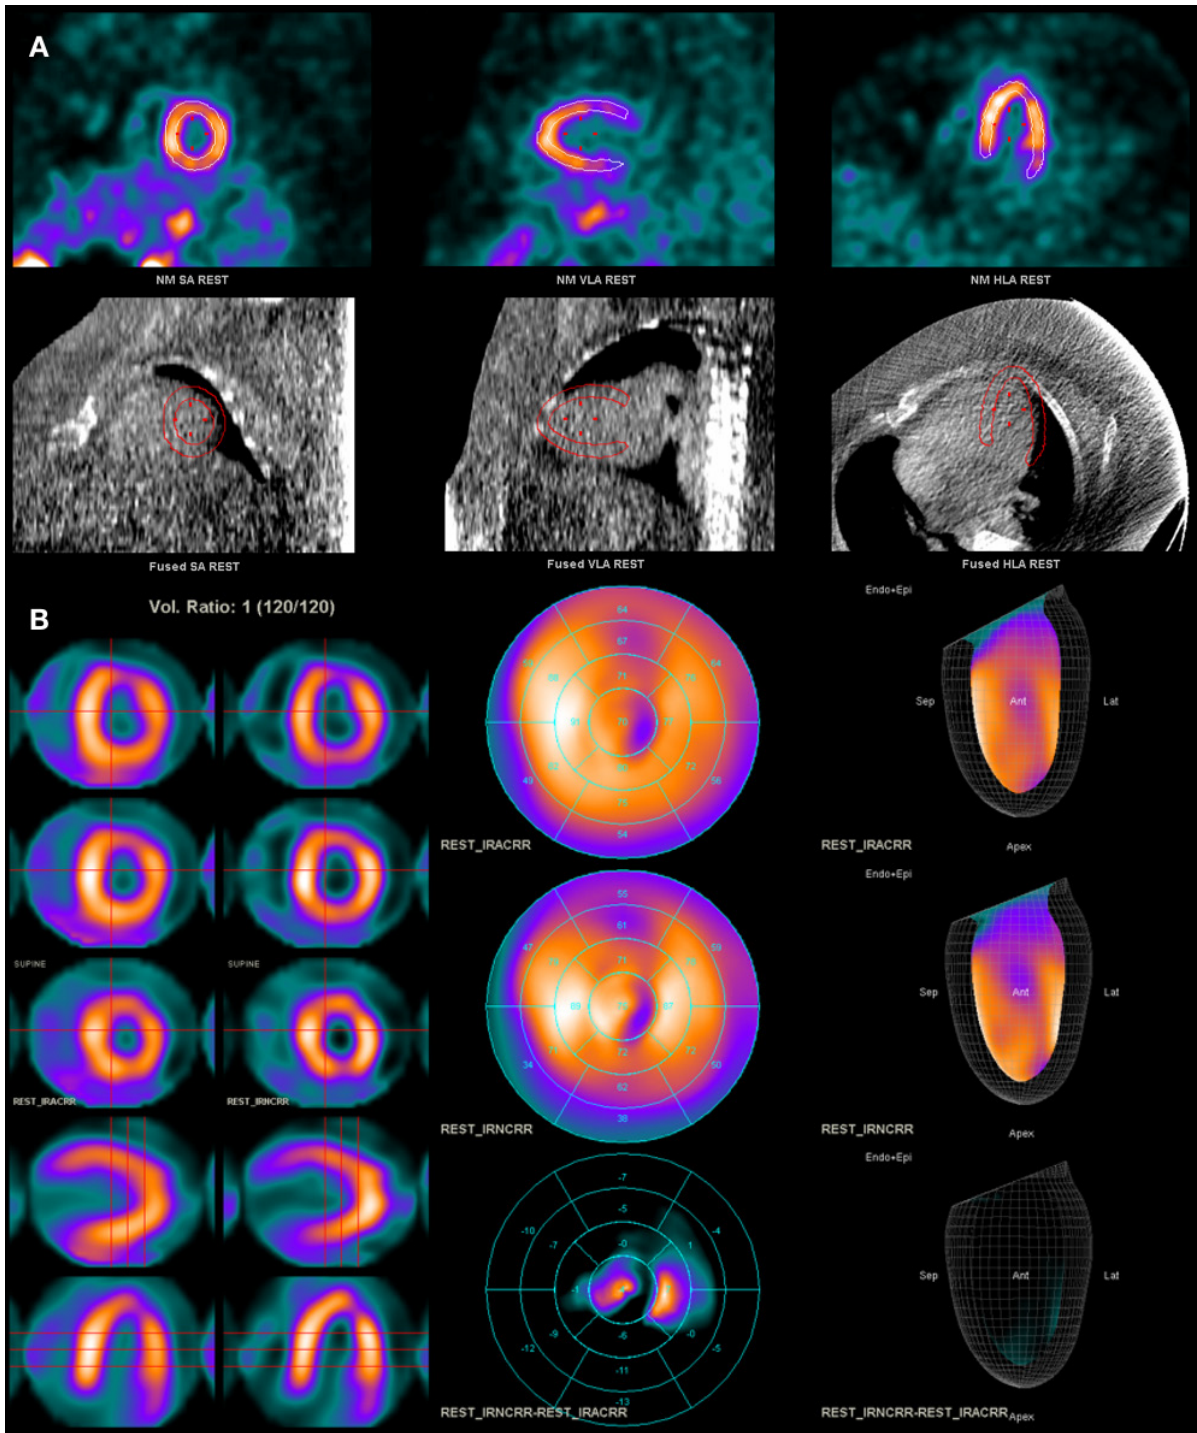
(A) Myocardial perfusion SPECT/CT study showing misregistration between the emission and CT for attenuation scan and (B) the resulting AC images and polar maps from this misregistration (IRACRR) together with NAC (IRNCRR).
